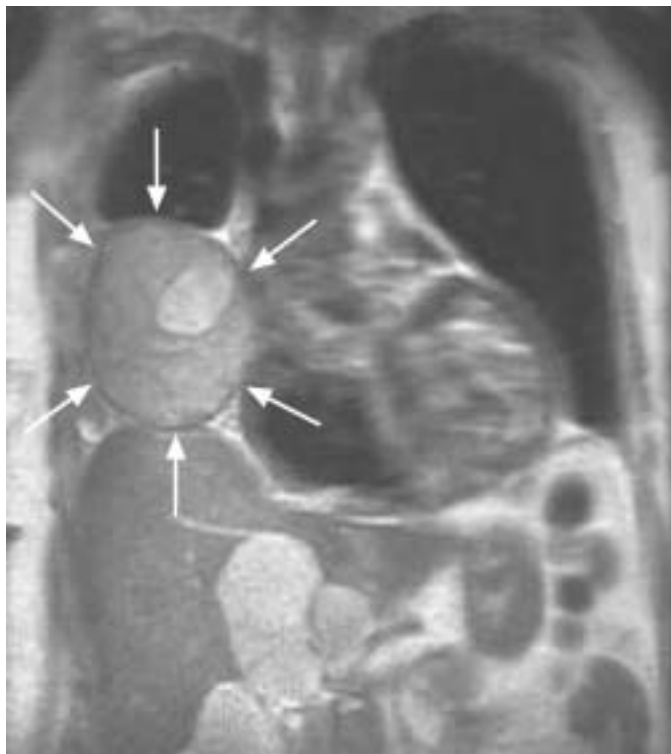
Magnetic resonance tomography of the chest and abdomen (T2-weighted image).
